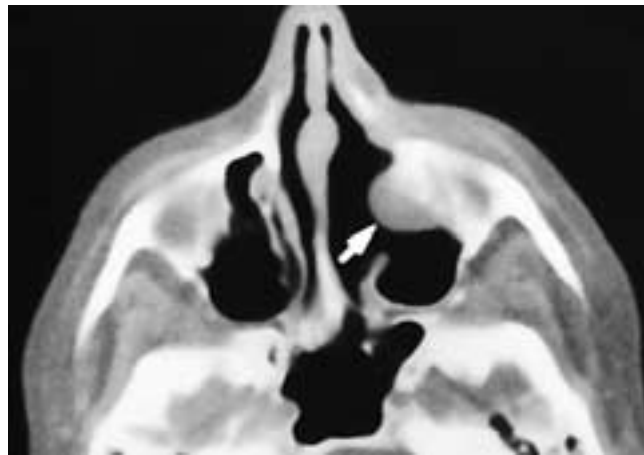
Axial CT scan on a patient after partial left maxillectomy with a smooth nodular mass (*arrow*) in the antrum. Although this could be an inflammatory mass, tumor should be suspected until proven otherwise. This patient had tumor recurrence.
